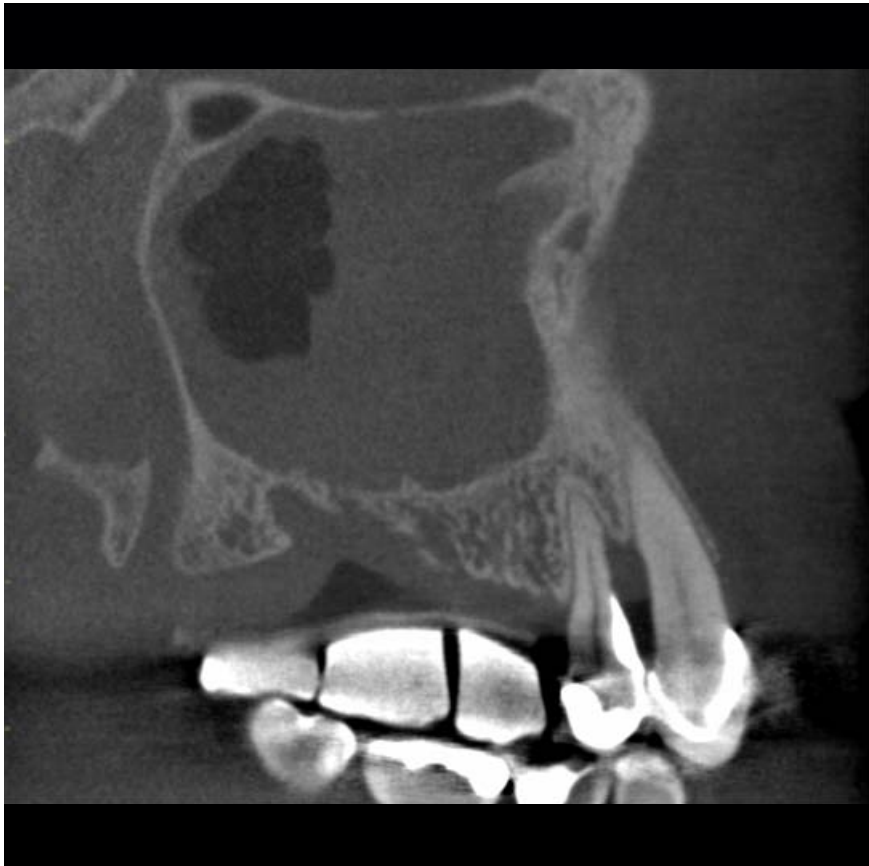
Sagittal CBCT image
